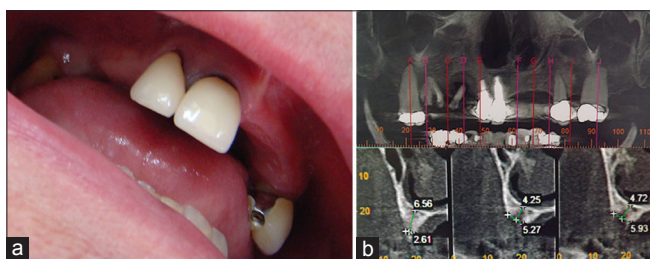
Initial clinical (a) and radiographic (b) exam showing a vertical and horizontal buccal bone defect
